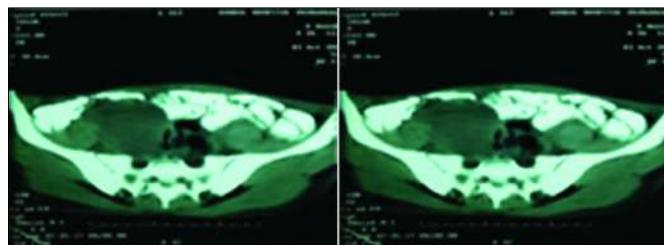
CT-scan showing pelvic mass.
